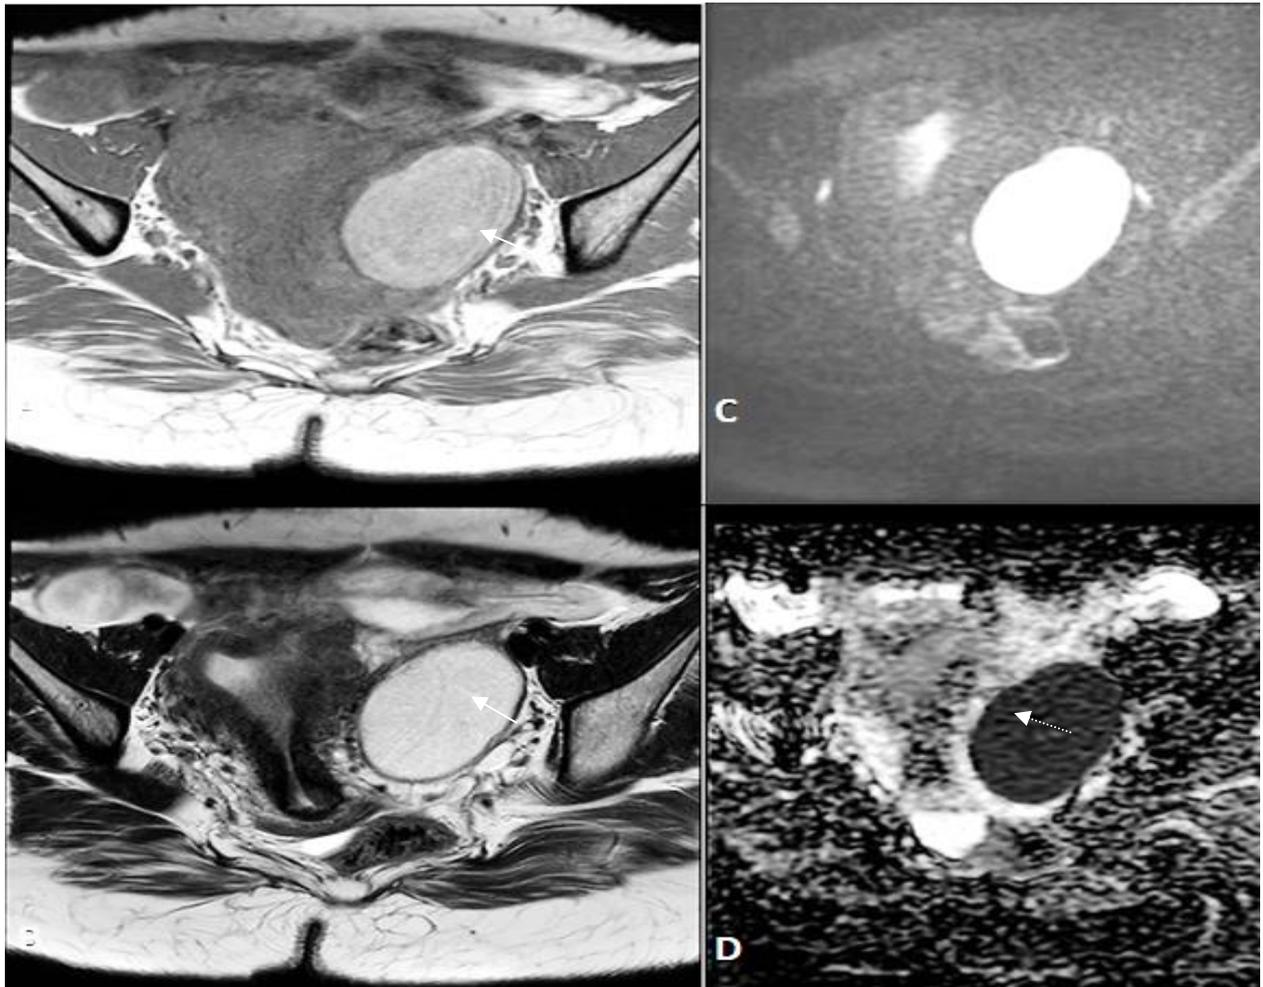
(A) (B) (C) (D)-Well-defined smoothly margined solid mass lesion noted in the left adnexa. T1/T2 hyperintense (arrow) and showing DWI restriction (dashed arrow). On HPE the lesion was identified as the dermoid cyst.
